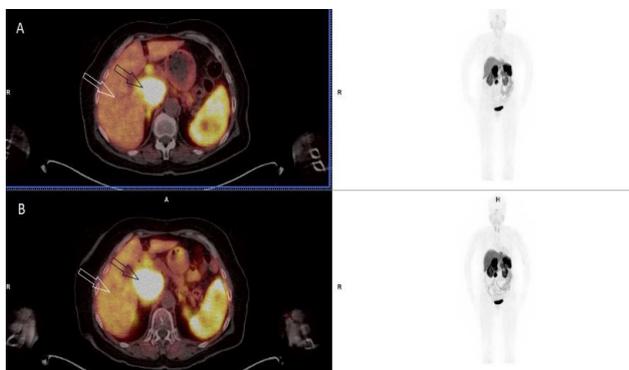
A 75-year-old female patient diagnosed with a pancreatic neuroendocrine tumor, 30 mg of lanreotide (Somatuline autogel/4 weeks) for 18 months before (A) and after (B) ⁶⁸Ga-DOTATATE PET/CT whole-body maximum-intensity projection (MIP) images. The lesion in the pancreas (black arrow) shows similar uptake in the pre-treatment (SUVmax: 39.10) and post-treatment (SUVmax: 42.26) images. A slight decrease is noted in the liver (white arrow). It is similar in other normal target organs.
